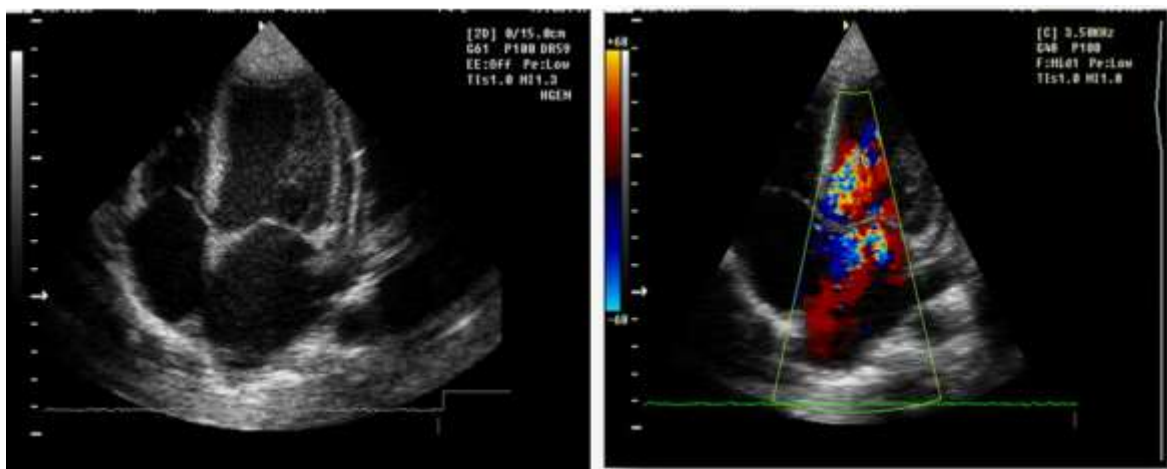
Echocardiography 4 chamber transthoracic apical view: echodense mitral and aortic valve, II-degree mitral regurgitation and Ist degree aortic regurgitation, pulmonary and tricuspid valve echodense, with I degree regurgitation. Left atrium and Left ventricle dilatation, normal kinetics, EF 70%, inferior vena cave not dilated, with inspiratory collapse, E/A > 2.
